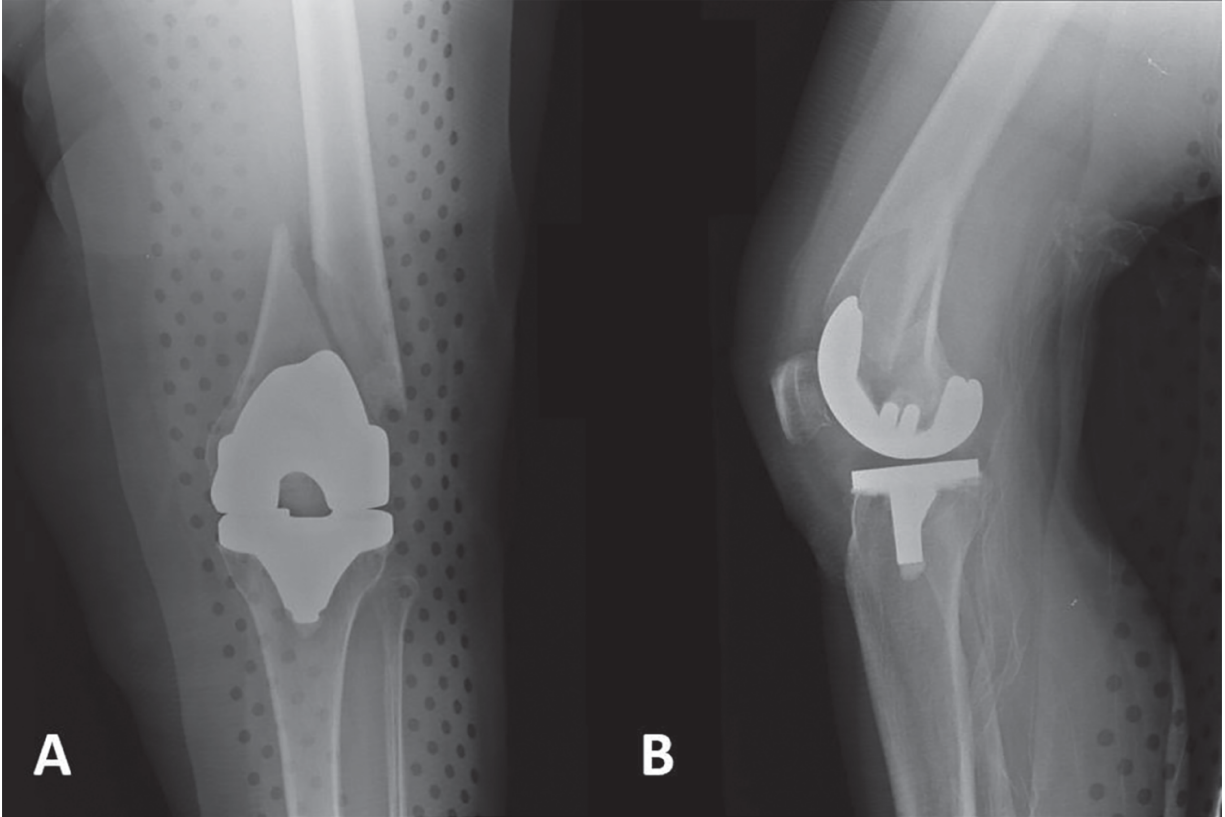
Preoperative radiographs of a 78-year-old female patient demonstrating a distal femur periprosthetic fracture above a previously well-functioning TKA (A and B). Nine-month postoperative radiographs demonstrating healing following treatment with locked plating (C-E).
